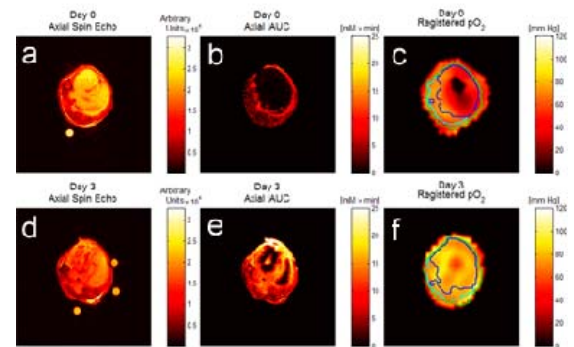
Example of images before (a, b, and c) and after TNF + IR treatment (d, e, and f). Spin echo (T<sub>2</sub>) MRIs are shown in (a) and (d). The initial AUC is shown in (b) and (e). Registered EPR oxygen images are shown in (c) and (f) with contours from MRI overlaid. Blue contour denotes the tumor, cyan denotes non-tumor, and green is the outline of the leg.
